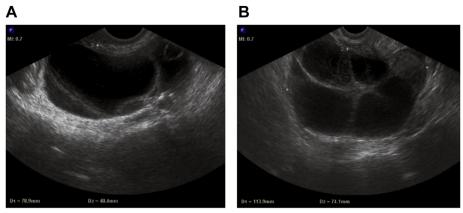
A 39 years old female presented with complaint of lower abdominal discomfort. Her transvaginal sonography at admission showed a multilocular cyst in left ovary (a) and in right side (b).
